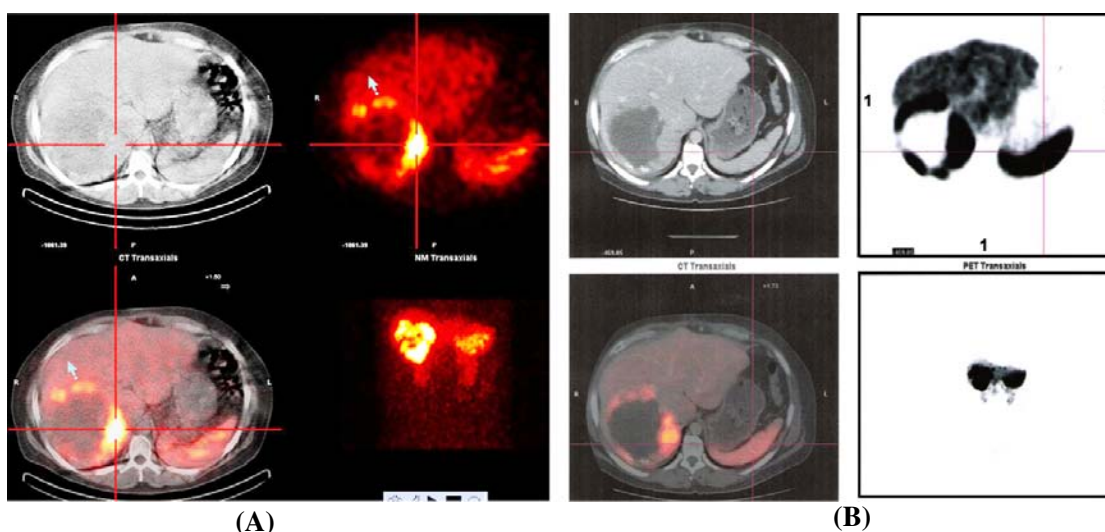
(A) SPECT-CT scan of a patient recorded after administration of 10 mCi (370 MBq) of ^{177}Lu -DOTA-TATE. (B) PET-CT scan of the same patient recorded after administration of ^{68}Ga -DOTA-TOC.
